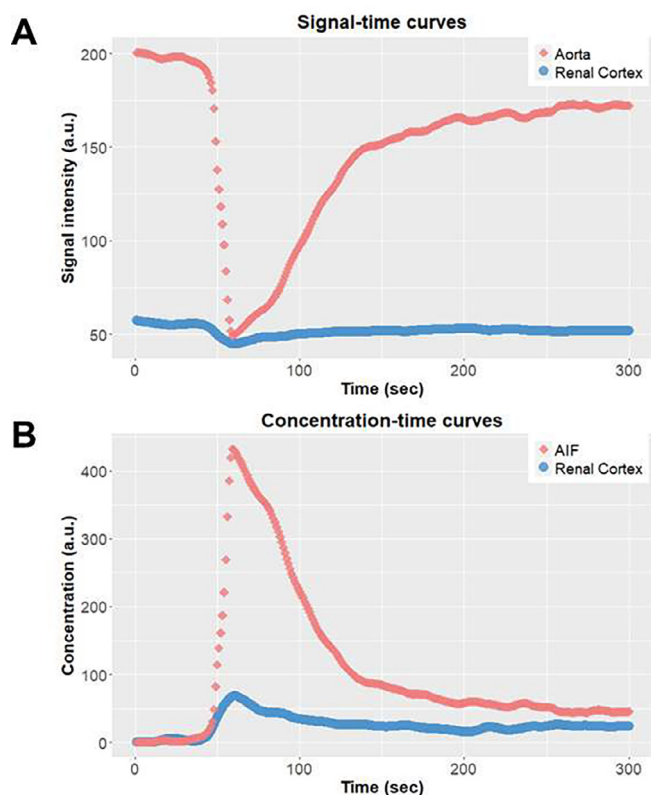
Representative data postprocessing of perfusion MRI. (A) Signal-time curves (STCs) are derived from aorta and renal cortex ROIs after injection of 250 nm PEG(+) MNPs. (B) Concentration-time curves (CTCs) are converted from the respect STCs. The CTC of aorta is known as arterial input function (AIF).
